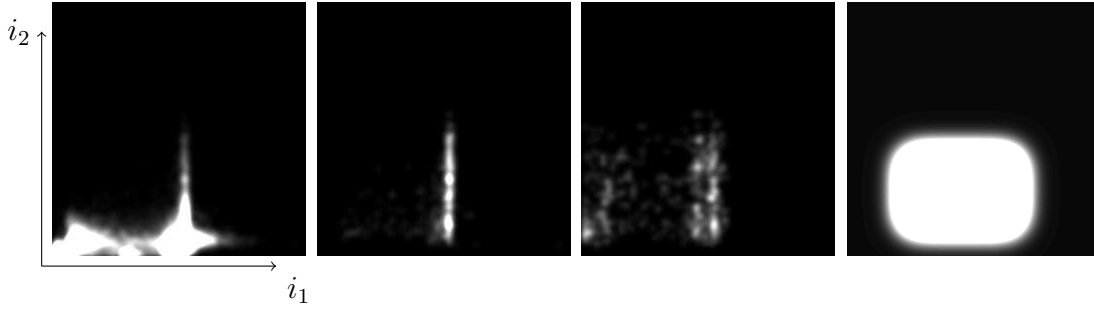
Observed joint pdfs of cardiac SPECT/CT data. From left to right, the distributions are displayed for the full volume overlap, the heart overlap, and the heart overlap at misalignment. The rightmost image presents the penalty term ω of eq. (3.35) that is generated from the observations made in two middle images.
